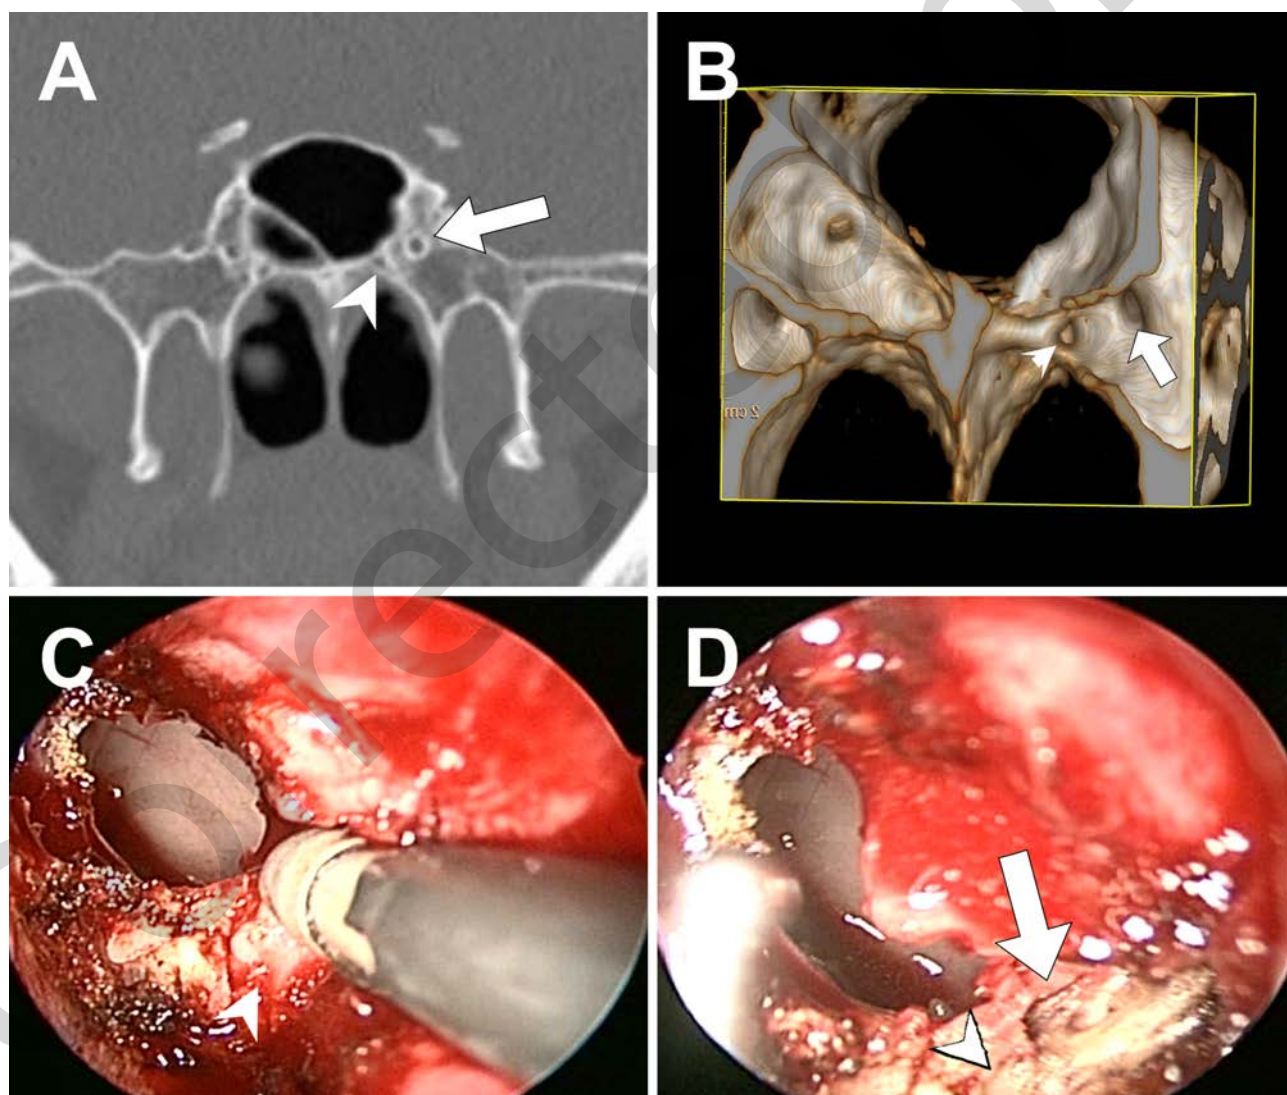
The left side palatovaginal canal (arrow head) located medially to the vidian canal (white arrow) is clearly demonstrated on A: coronal CT slice; and even more realistically in B: 3D reconstruction image. The intraoperative endoscopic view delineates the close relationship of those two nerves (C, D), which may confuse the novice surgeon.
